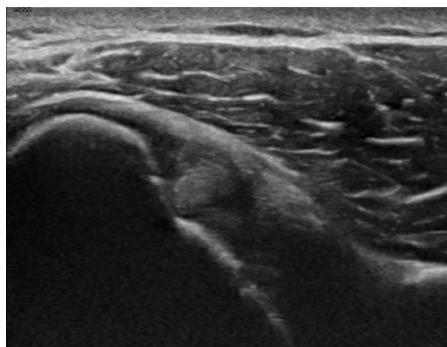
Ultrasound image showing raised echogenicity in rotator interval. Image 4: Ultrasound image showing long head of bicep brachii tendon effusion
